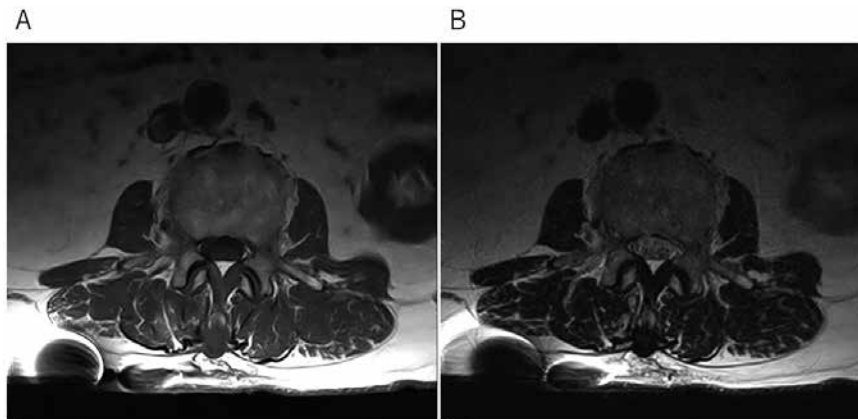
Representative magnetic resonance images obtained with the CERTAS Plus valve implanted in the paravertebral muscle of the back. The spinal structures or spinal cord can be seen even with valve artifacts on T1-weighted images (A) and T2-weighted images (B).
